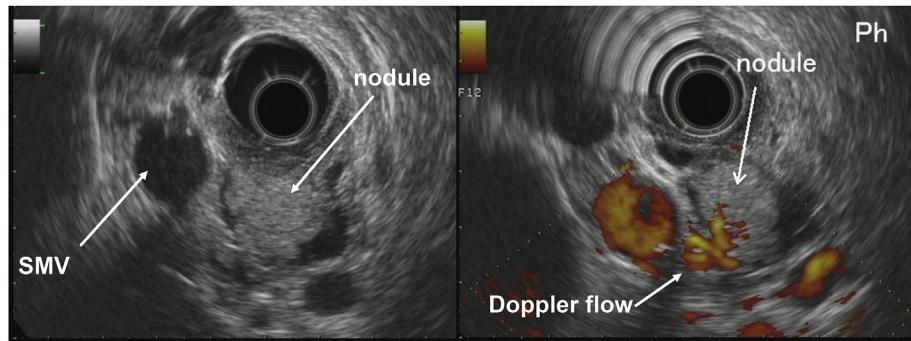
Endoscopic ultrasonogram showing a mural nodule in the dilated main pancreatic duct with Doppler flow indicating the presence of a blood supply.
